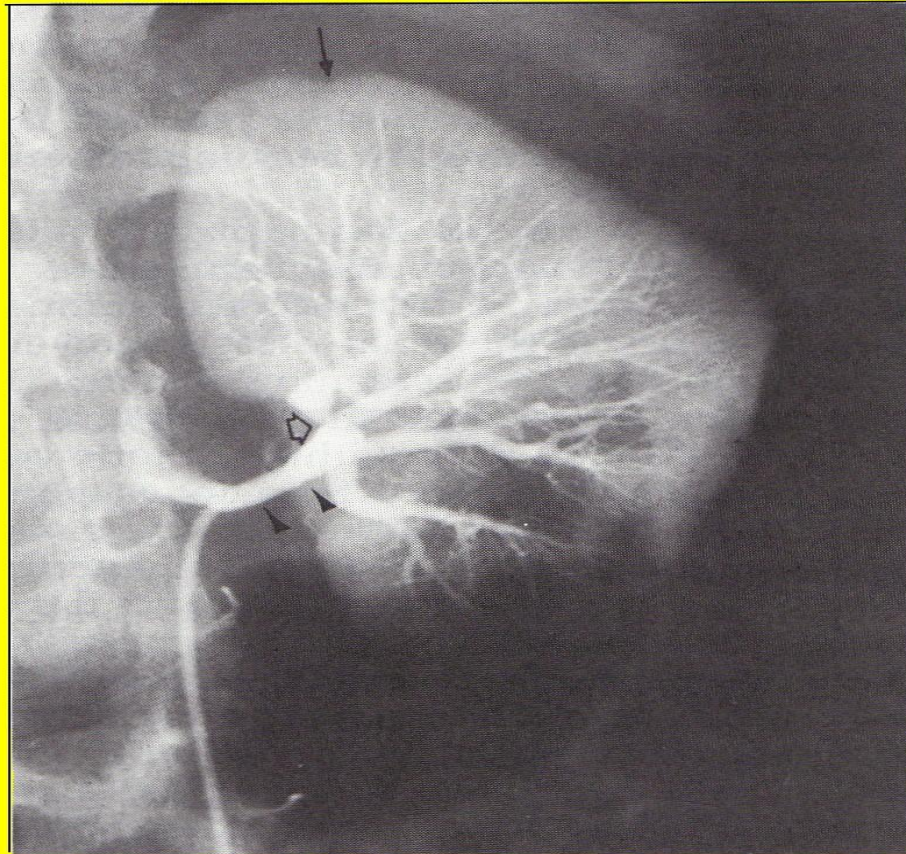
This 4.5-year-old girl with renal artery stenosis presented with severe hypertension and headaches. Results of renal sonography were normal. Renal arteriography was requested. During selective injection of the left renal artery, a severe, focal stenosis at the origin of an upper pole lobar artery was demonstrated (*open arrow*). There is also more subtle, irregular narrowing of the main renal artery (*arrowheads*), consistent with fibromuscular dysplasia. A notchlike defect in the upper pole of the kidney represents a parenchymal infarct (*arrow*).
